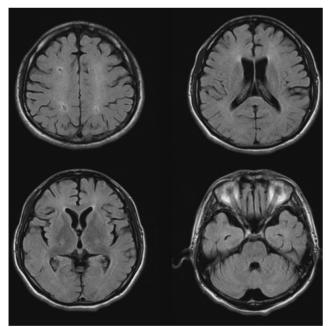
Brain MRI 5 months (day 151) after the onset of the insult showed regression of the white matter lesions but presence of mild cortical atrophy.
